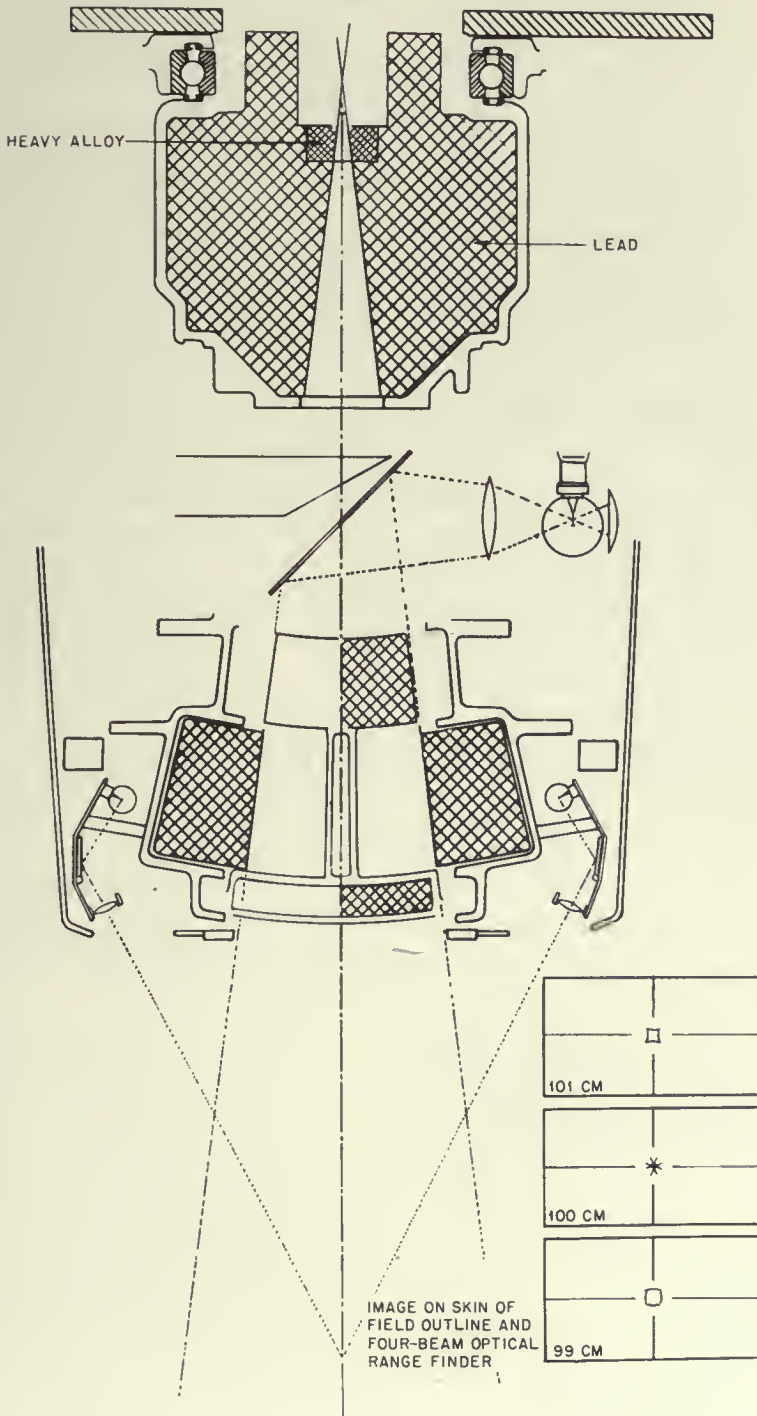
The 4 million volt X-ray head, showing pivoted diaphragms to minimize penumbra and optical systems to center and outline the beam.
